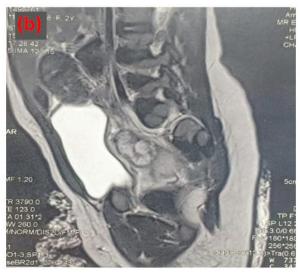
Transverse (a) and sagittal (b) abdominopelvic MRI image showing a pre-rectal mass of a hemorrhagic nature
